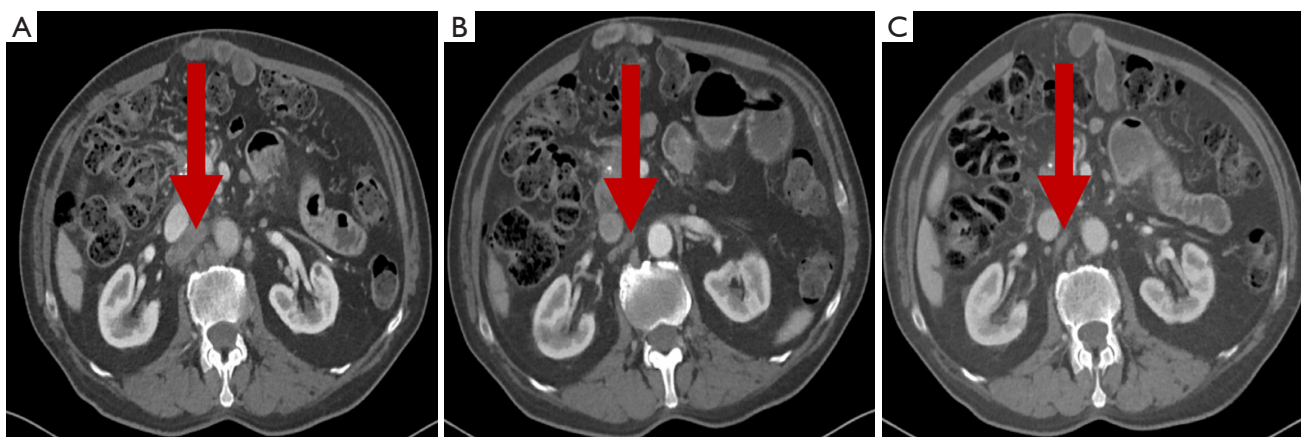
Radiographic response to talazoparib. Selected axial images from serial computed tomography scans demonstrating complete radiographic response. (A) Representative image of retroperitoneal lymphadenopathy (interaortocaval node measuring 13.8 mm × 40.9 mm, red arrow) 1 month prior to talazoparib. (B) Decrease in lymphadenopathy to 7.2 mm in short-axis diameter (red arrow) after 4 months of talazoparib. (C) Resolution of retroperitoneal lymphadenopathy (red arrow) without evidence of disease in the chest, abdomen, or pelvis after 8 months of talazoparib.
